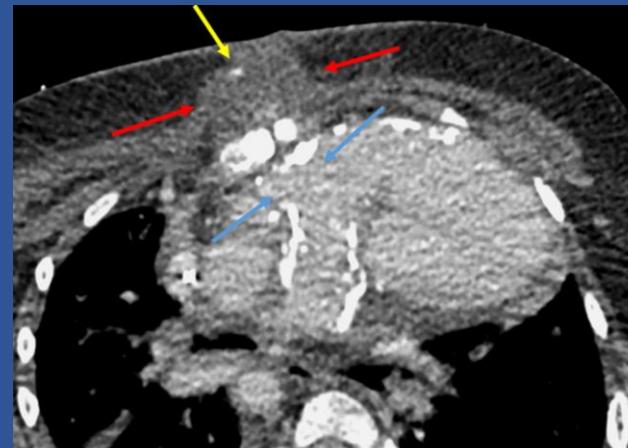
CT of the Chest with IV Contrast: Axial image at the level of the right ventricular outflow tract. There is a pseudoaneurysm (blue arrows) of the RV to PA conduit that has ruptured and decompressed into the subcutaneous anterior chest wall with subsequent subcutaneous pseudoaneurysm formation (red arrows). There is active bleed within this (yellow arrow).
